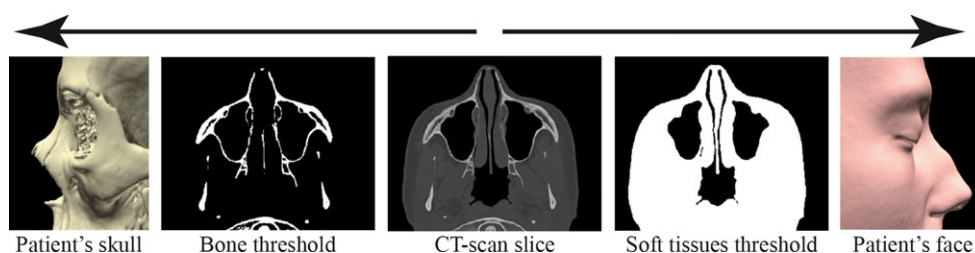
Extraction of three-dimensional surfaces from CT scans using the HMH 3D algorithm (19) in TIVMI.
